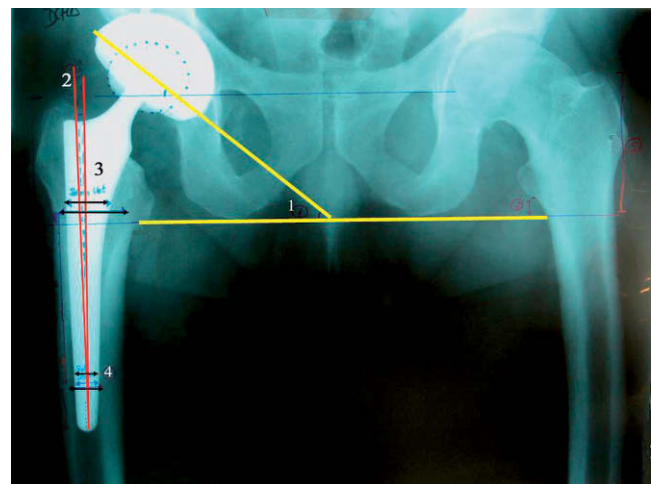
Radiographic measurements performed (Bihapro-Cerarfit). 1) Angle of the acetabular component in relation to the bischiatric line. 2) Angle of the femoral component in relation to the femoral diaphyseal axis. 3) Metaphyseal filling. 4) Diaphyseal filling.
